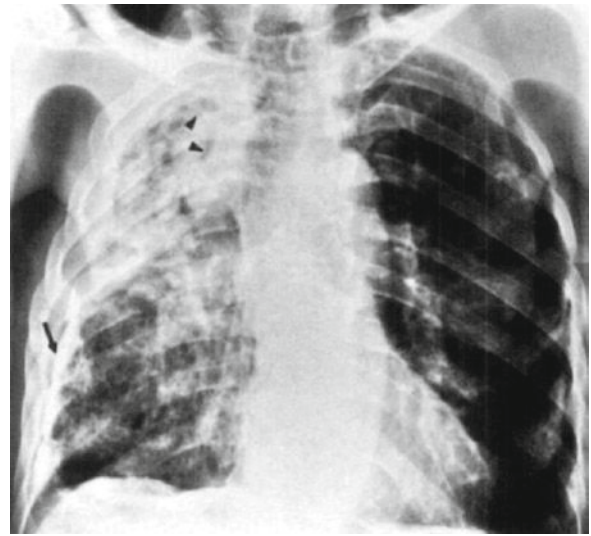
Shows an *Aspergillus* ball in a tuberculous cavity on a chest X-ray
